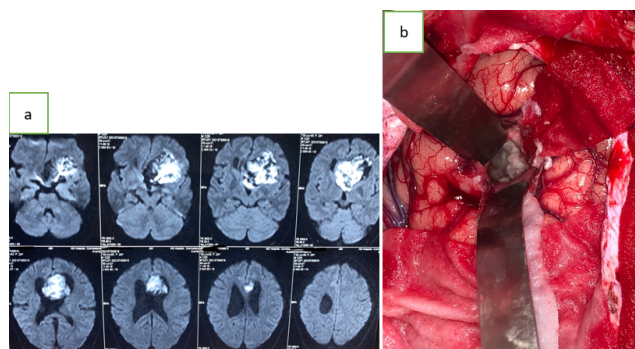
a: MRI Brain showed a well-defined lesion in the frontal horn of left lateral ventricle with mass effect measuring 3.3x2.0 cm; b: left frontal craniotomy, through transcortical approach and total excision of the lesion was done
